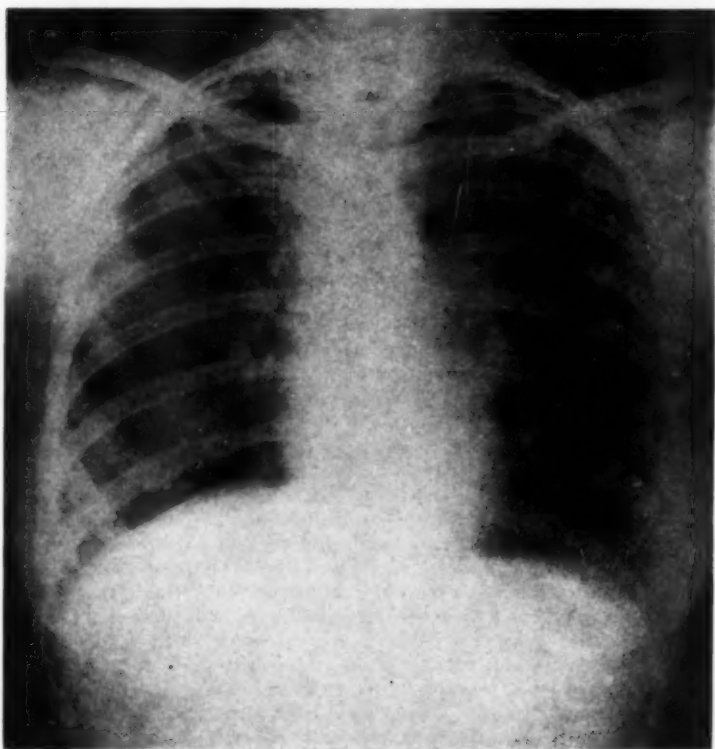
Chest roentgenogram taken August 19, 1947, showing cavities at the right apex, right base and left root.
